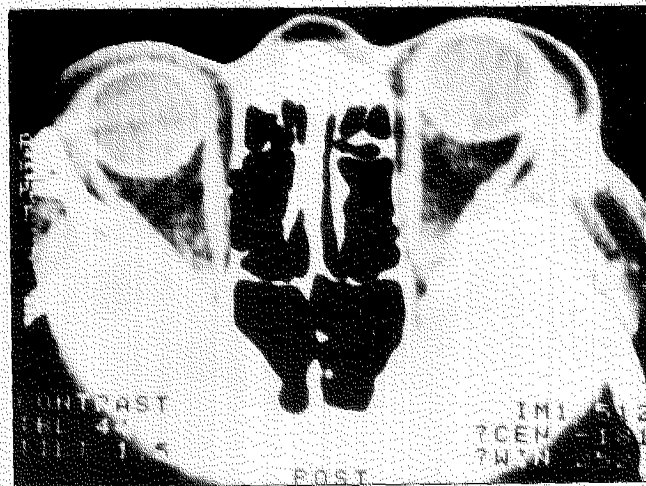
SINUS CT (PRETREATMENT)
